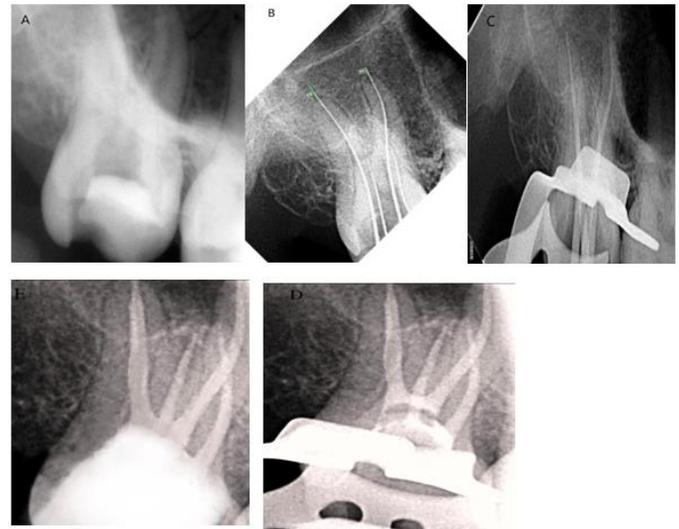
(A) preoperative radiograph of #17 showing carious involvement of pulp. (B) working length determination (C) Emphasizing working length by gutta percha cone. (D) final obturation. (E) follow up radiograph
